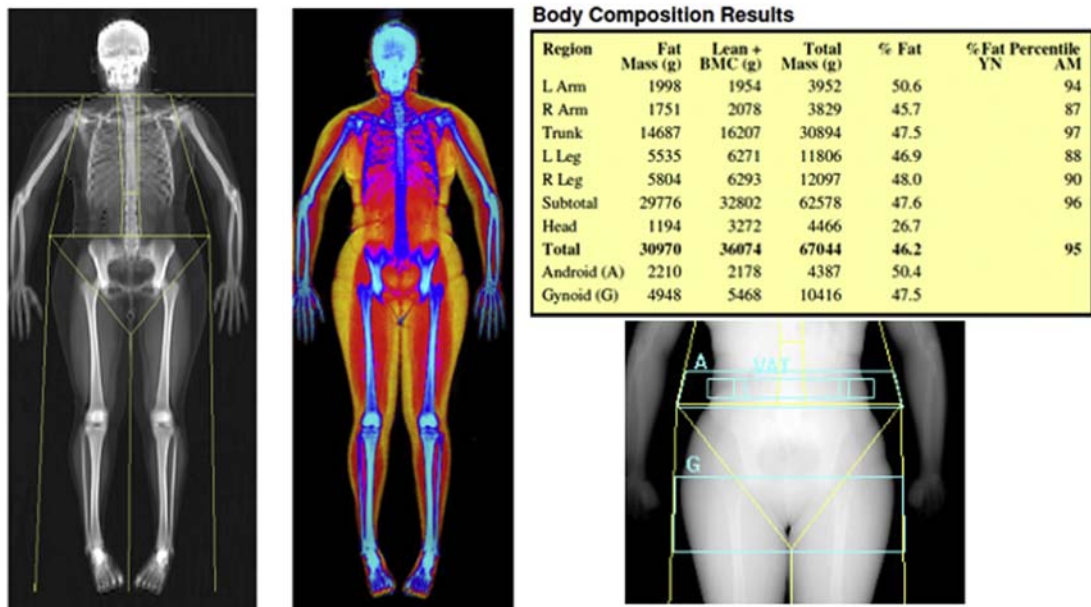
Dual energy X-ray absorptiometry (DXA).
